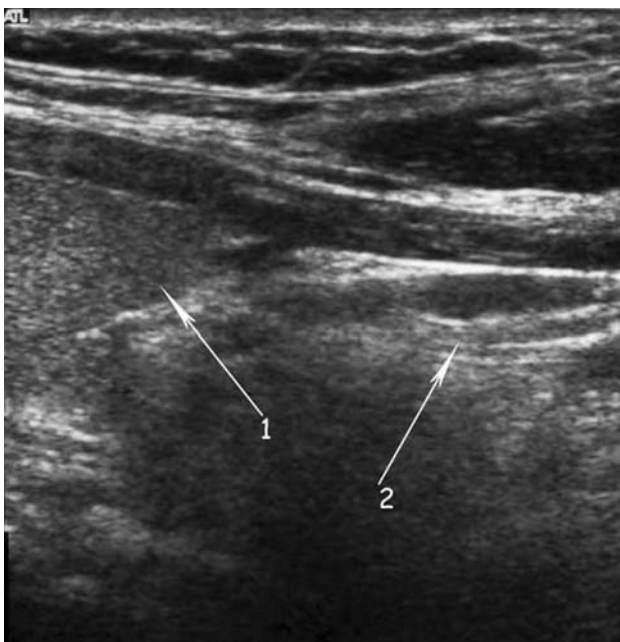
Ultrasonography. Arrow 1: inferior pole of right thyroid lobe. Arrow 2: right inferior parathyroid adenoma along thyrothymic ligament: position 3
